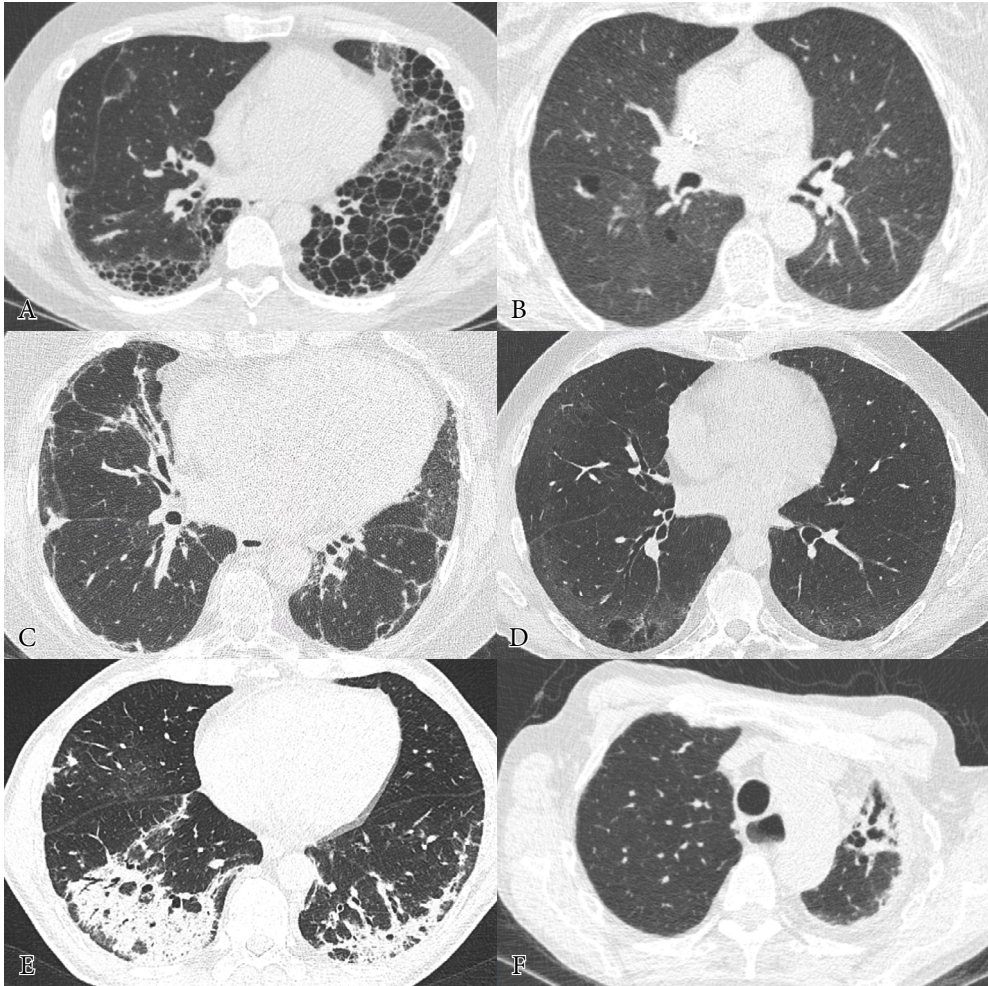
HRCT patterns in usual interstitial pneumonia (UIP, A), lymphocytic interstitial pneumonia (LIP, B), fibrotic nonspecific interstitial pneumonia (fNSIP, C), cellular NSIP (D), organising pneumonia (OP) and Pleuroparenchymal fibroelastosis (PPFE, F). The images were from our patients reported in Chapter 2.
